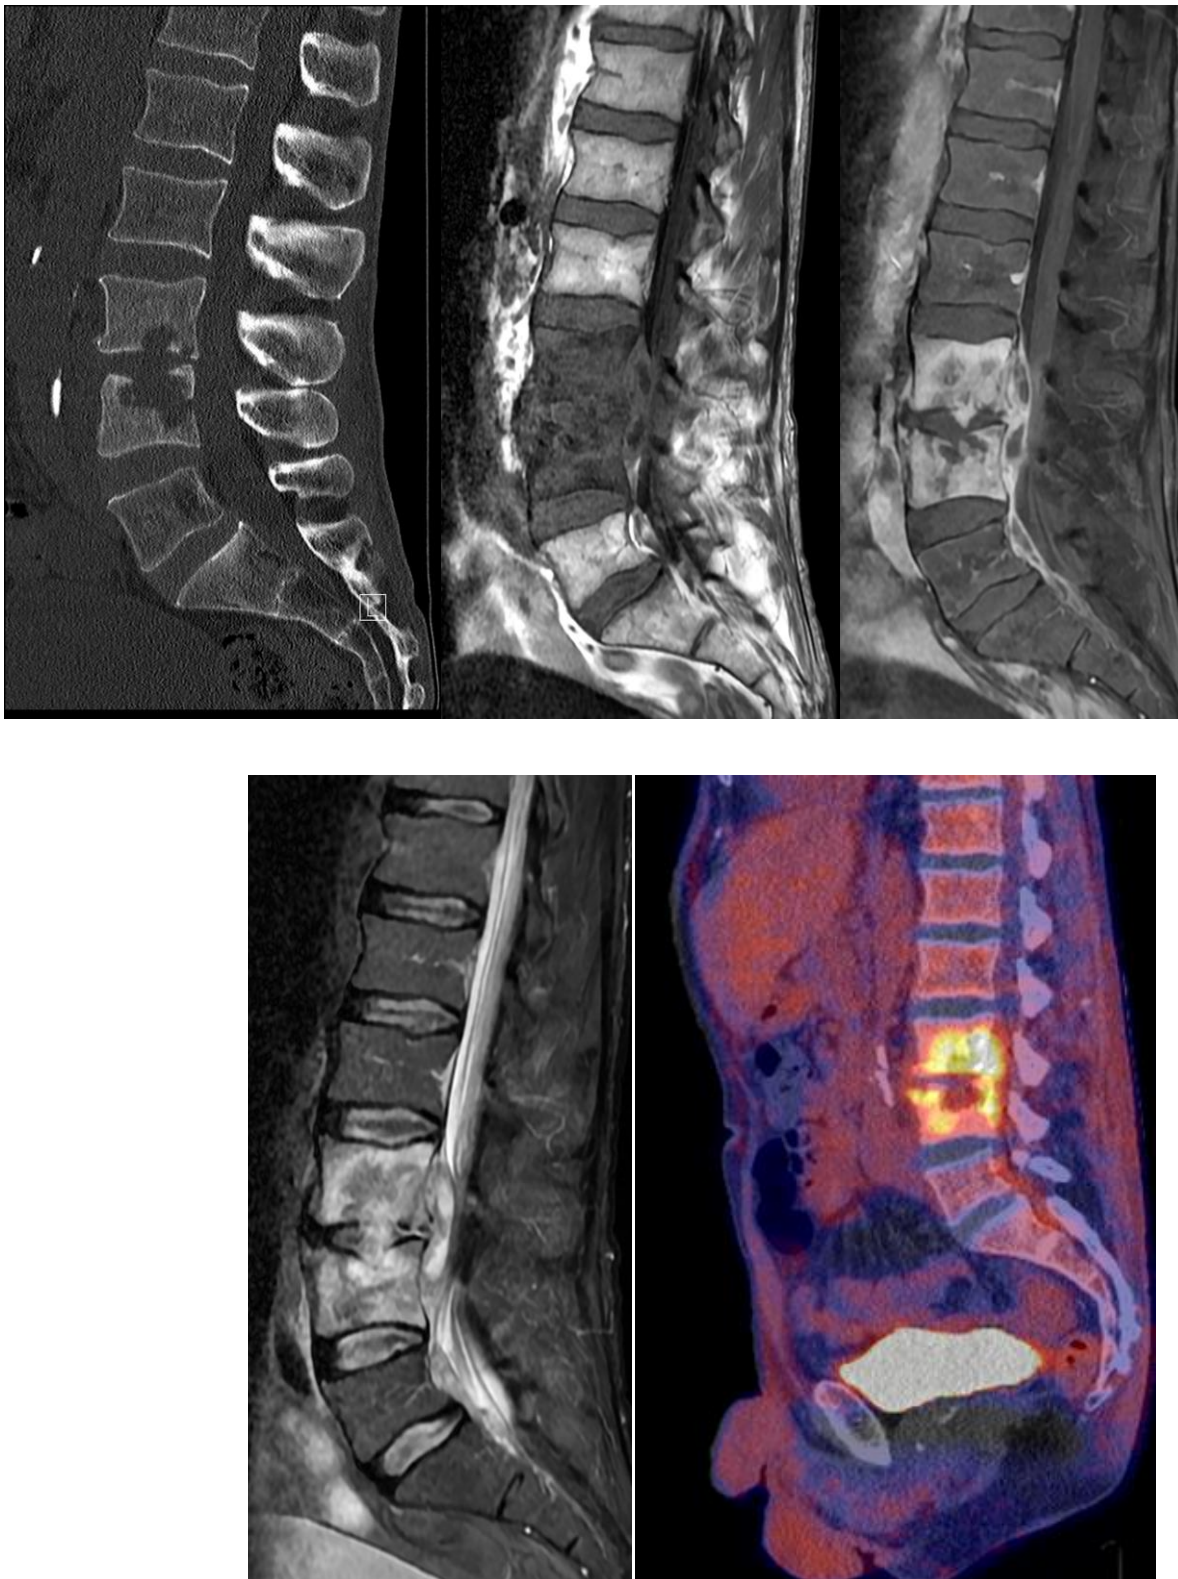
(a) CT; (b) T1; (c) contrast-enhanced T1; (d) T2 with fat saturation; (e) FDG-PET/CT
